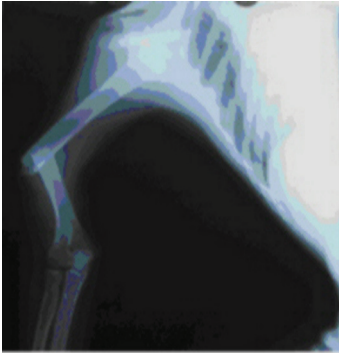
Anteroposterior radiograph showing an anterior dislocation of the right glenohumeral joint with ipsilateral fracture of humerus.
